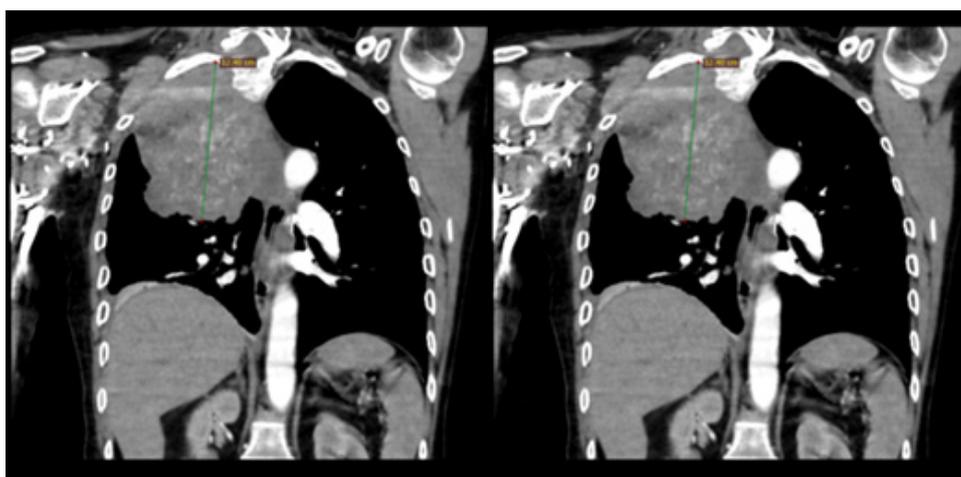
Coronal section computed tomography of the tumor shrinkage in a case with high PNI and low SIRI
